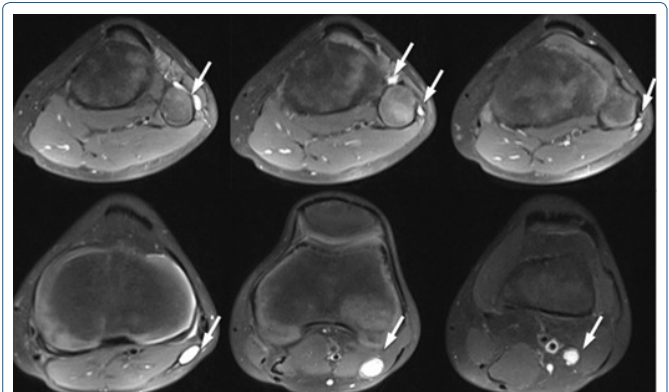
In radiological examination of the case, intraneural ganglion cyst, extending to proximal along the common peroneal nerve by attaching to deep and superficial branches of peroneal nerve, is shown in sequential MRI (2 mm) images obtained in liquid sensitive sequences in axial.
